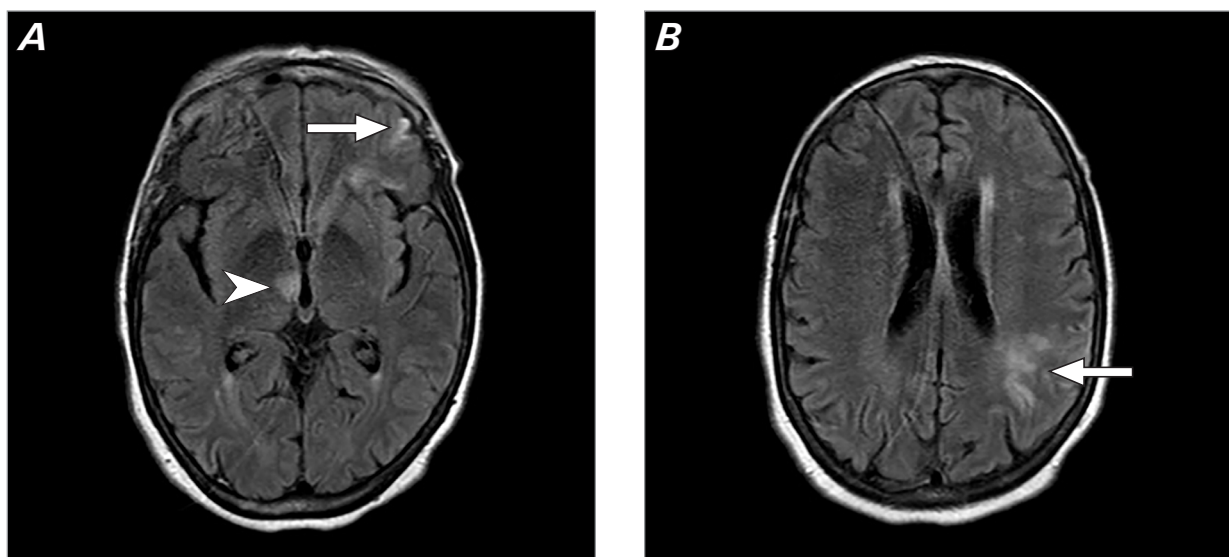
Diffusion-weighted magnetic resonance imaging in the axial plane without contrast reveals hyperintensities in the (A) right thalamus (arrowhead) and left frontal lobe (arrow) and (B) left parietal lobe (arrow).
